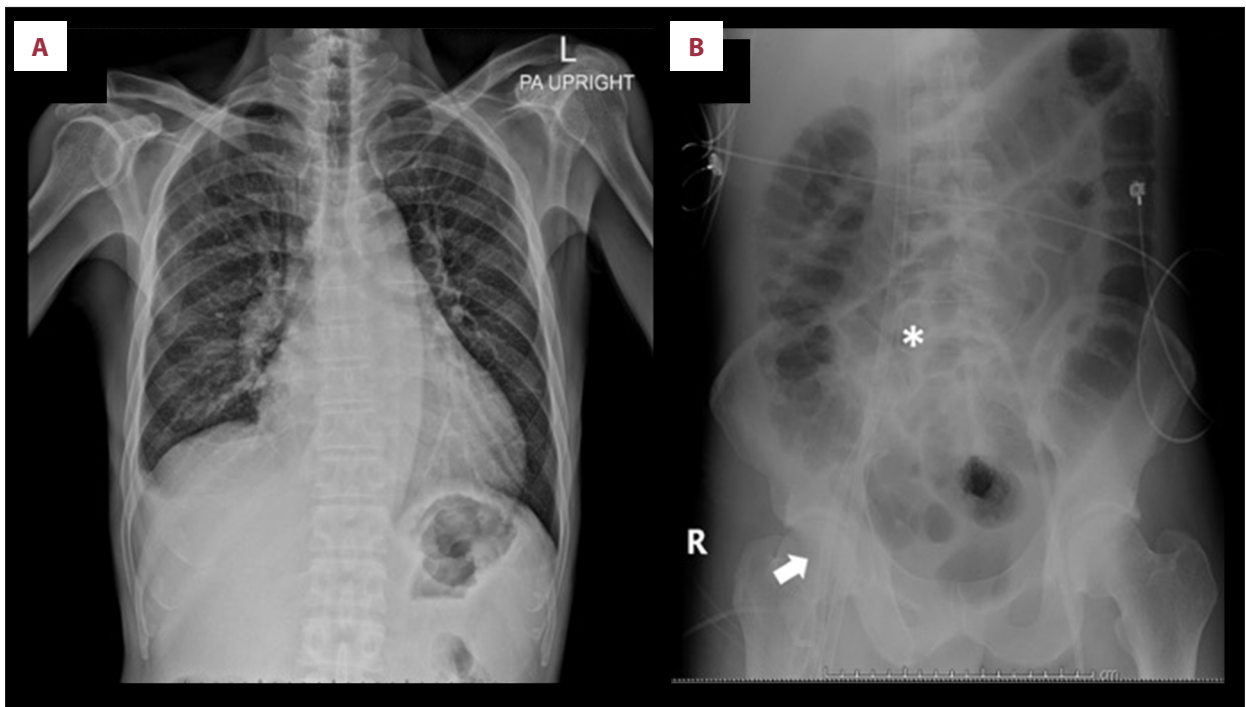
(A) Chest radiograph prior to ECMO showing cephalization (B) Abdominal X-ray showing inflow (asterixis) and outflow cannular (arrow) of the ECMO circuit in the inferior vena cava and the femoral artery, respectively.
